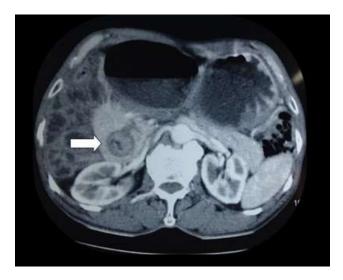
CT abdomen showing dilated stomach and first part of duodenum. The second part of the duodenum showed encirclement with annular pancreatic tissue (arrow) and luminalnarrowing.
